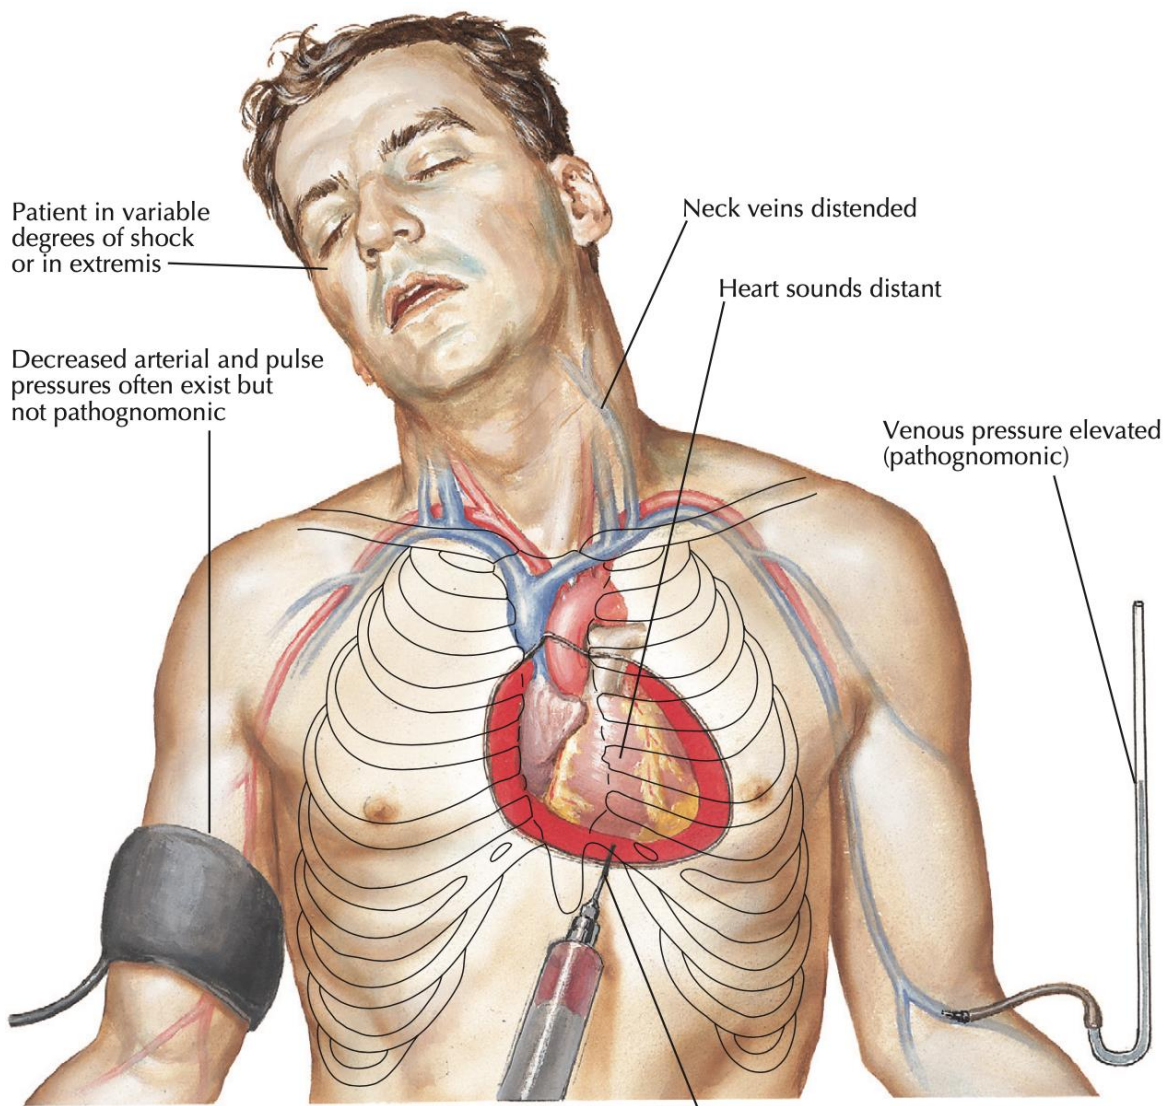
Cardiac Tamponade. A. Normal heart. B. Cardiac tamponade can result from penetrating or blunt injuries that cause the pericardium to fill with blood from the heart, great vessels, or pericardial vessels. C. Ultrasound image showing cardiac tamponade.
